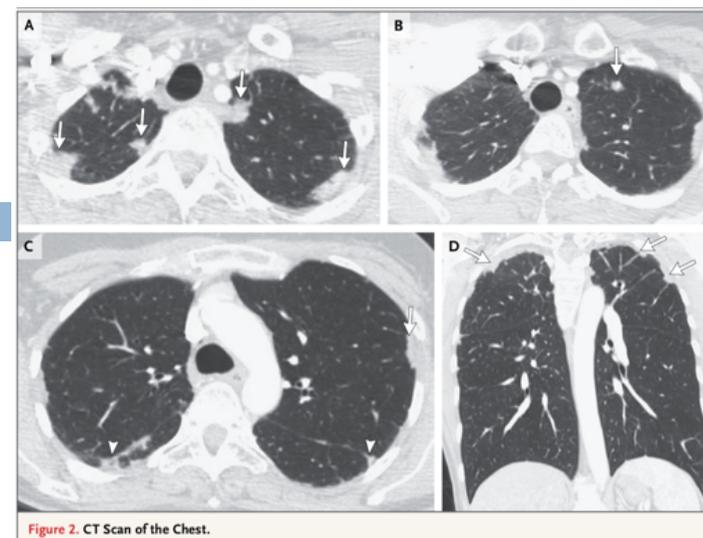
CT Scan of the Chest.
